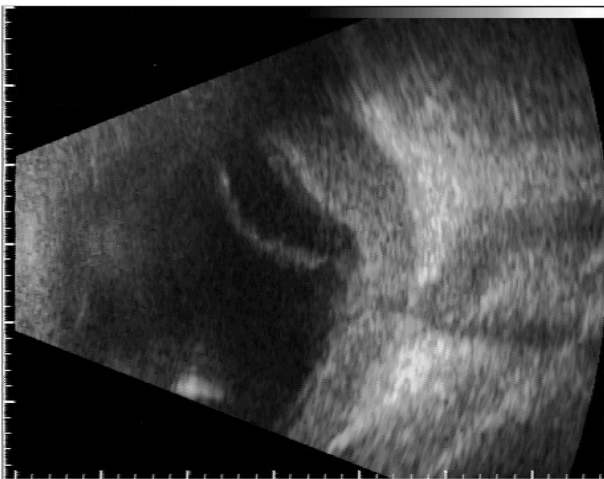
B-scan ultrasound of the left eye on the first visit of the patient to our hospital. Retinal detachment with choroidal thickening was apparent.
